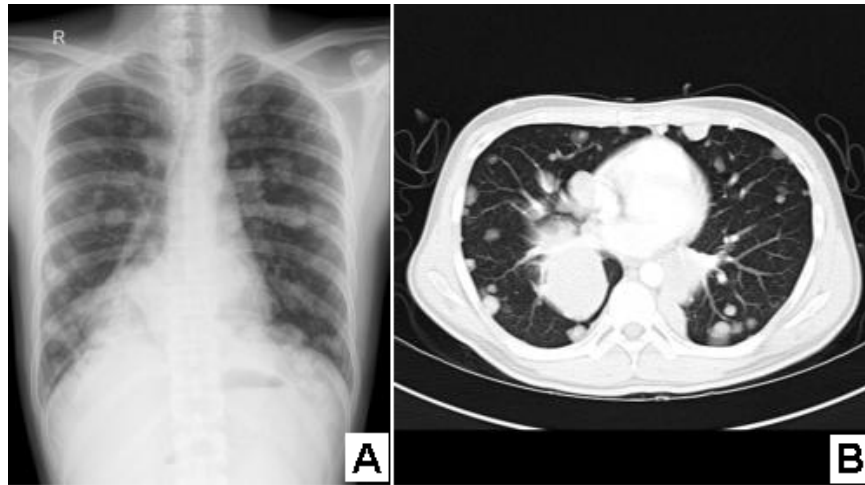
Chest Radiography (A) and CT scan (B). Chest radiography dan CT scan showed multiple nodules on both lungs, consistent with lung metastases
